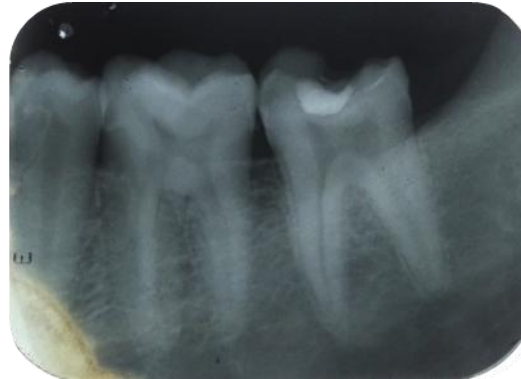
Diagnostic radiograph
